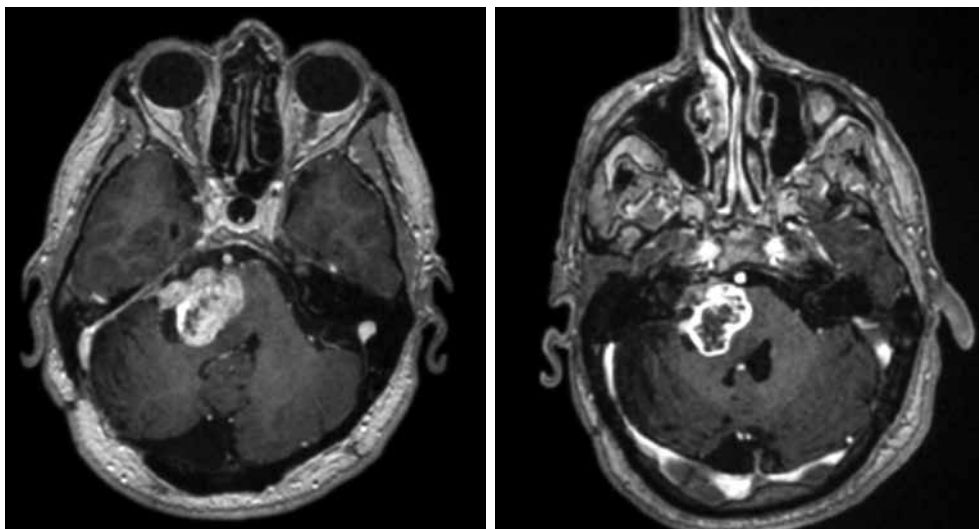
Three-dimensional, T1-weighted, fast spoiled gradient echo images demonstrating a tumor having type 1 appearance becoming more cystic (Type 3) after CyberKnife radiotherapy on final magnetic resonance imaging scan.
